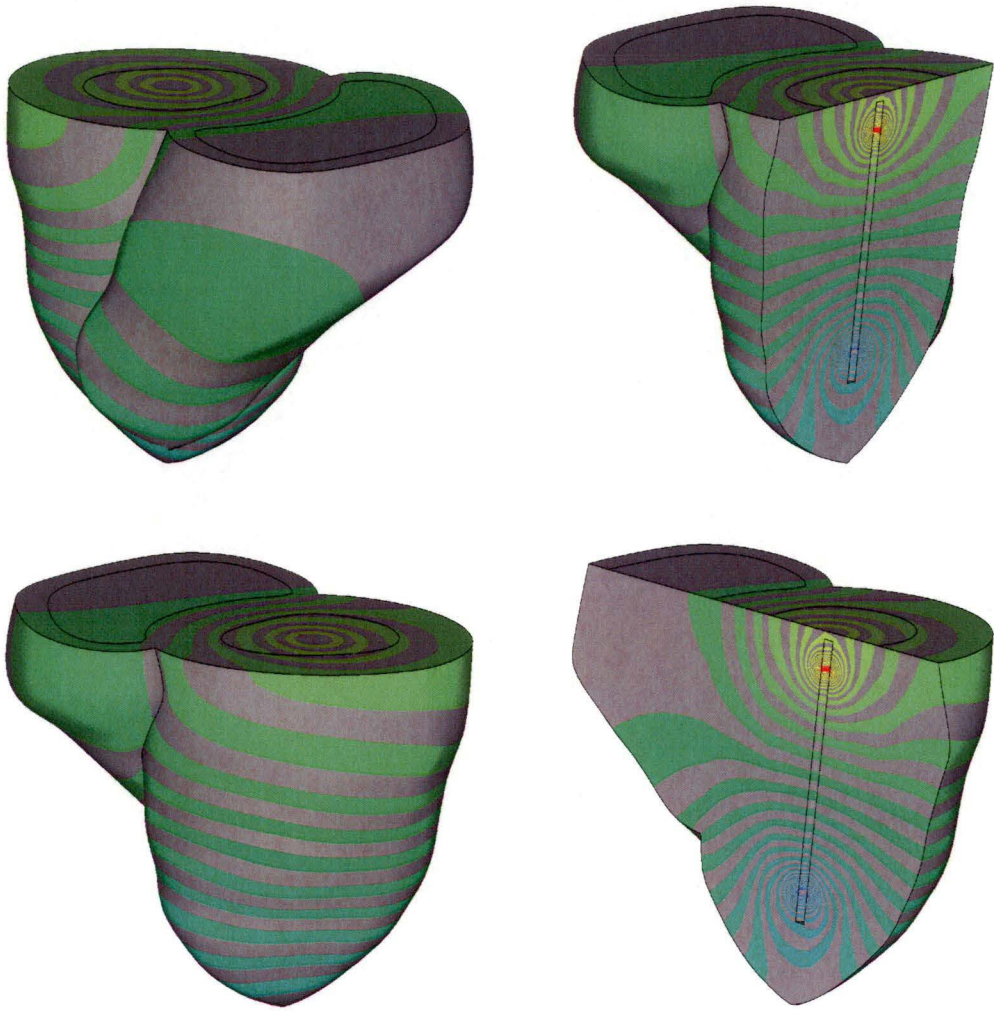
Left ventricle catheter voltage contours in tagged MRI model at end systole for blood conductivity/myocardium conductivity = 2.75.
